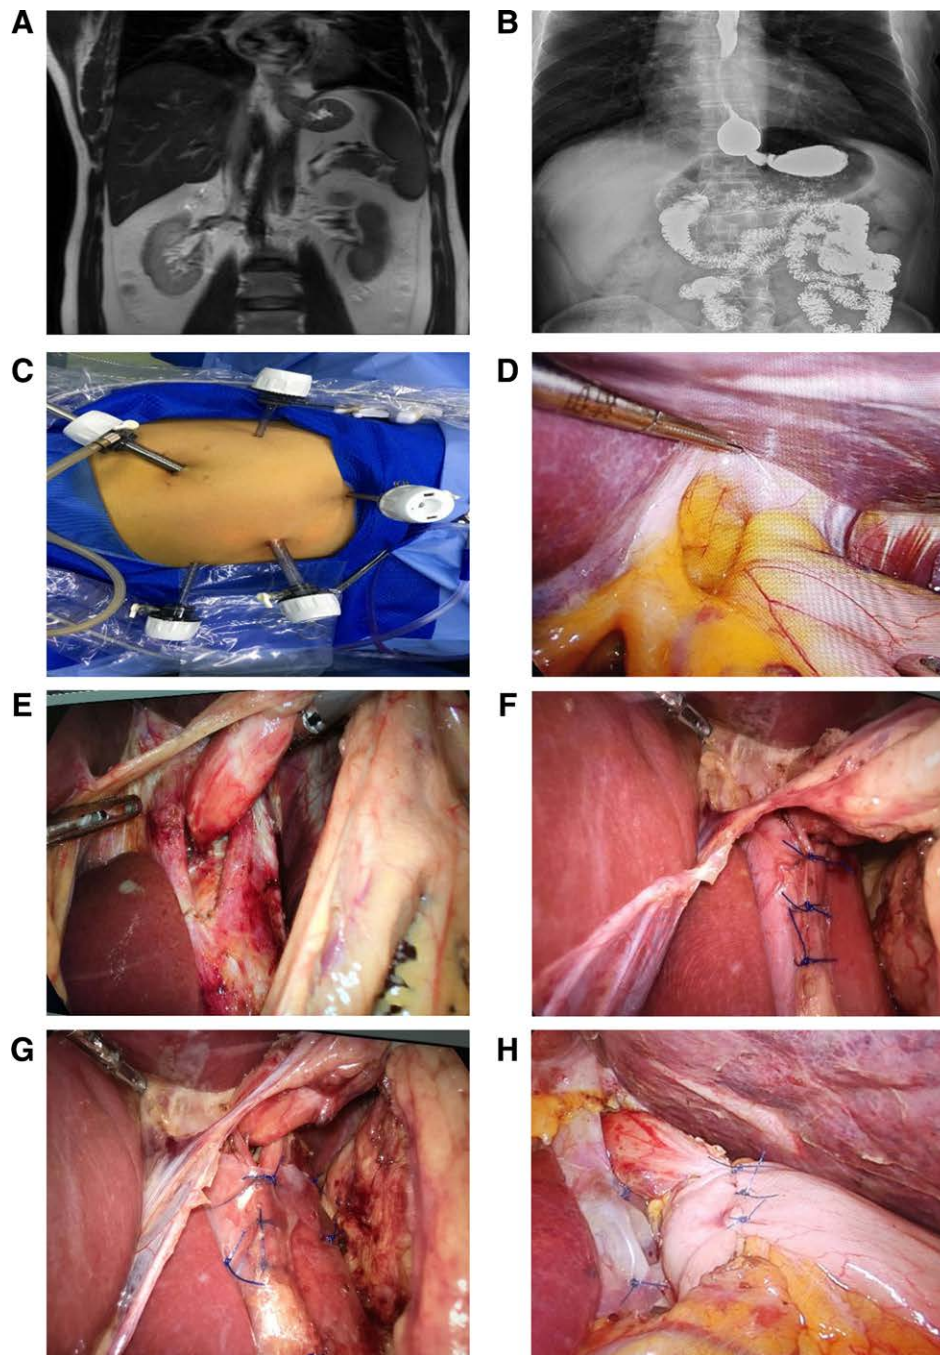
Surgery-related picture A: preoperative magnetic resonance imaging exhibits partial hernia of gastric fundus into esophageal hiatus; B: Barium meal of upper digestive tract indicates hiatal hernia; C: Trocar position layout; D: Restoration of hernia contents; E: Free esophagus and posterior space; F: Intermittent suture of diaphragm foot to reduce esophageal hiatus; G: Placement of biological mesh and fixation with silk thread; H: 360° Nissen fundoplication.
